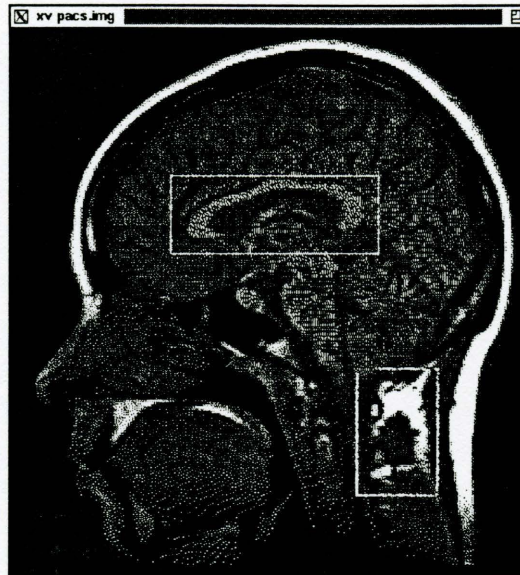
X-Ray Image with Variable Annotation
